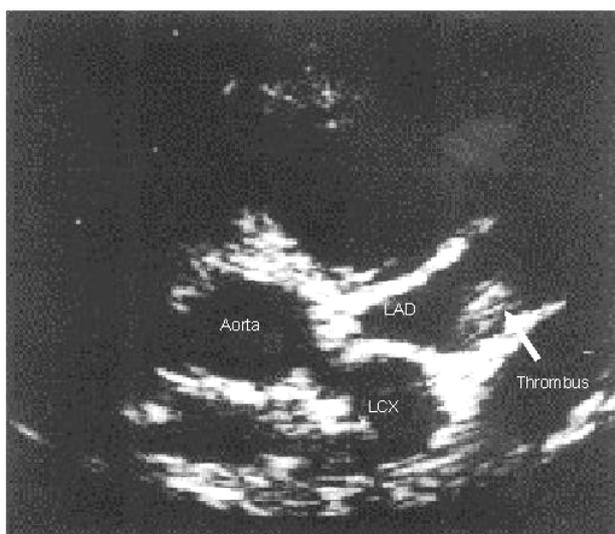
Dilated left anterior descending and left circumflex coronary arteries with aneurysm formation and a thrombus in the left anterior descending coronary artery seen on transthoracic echocardiography (short axis parasternal view). Courtesy of Prof. Maiy H. Elsayed, Professor of Cardiology, Faculty of Medicine, Ain Shams University, Egypt.
